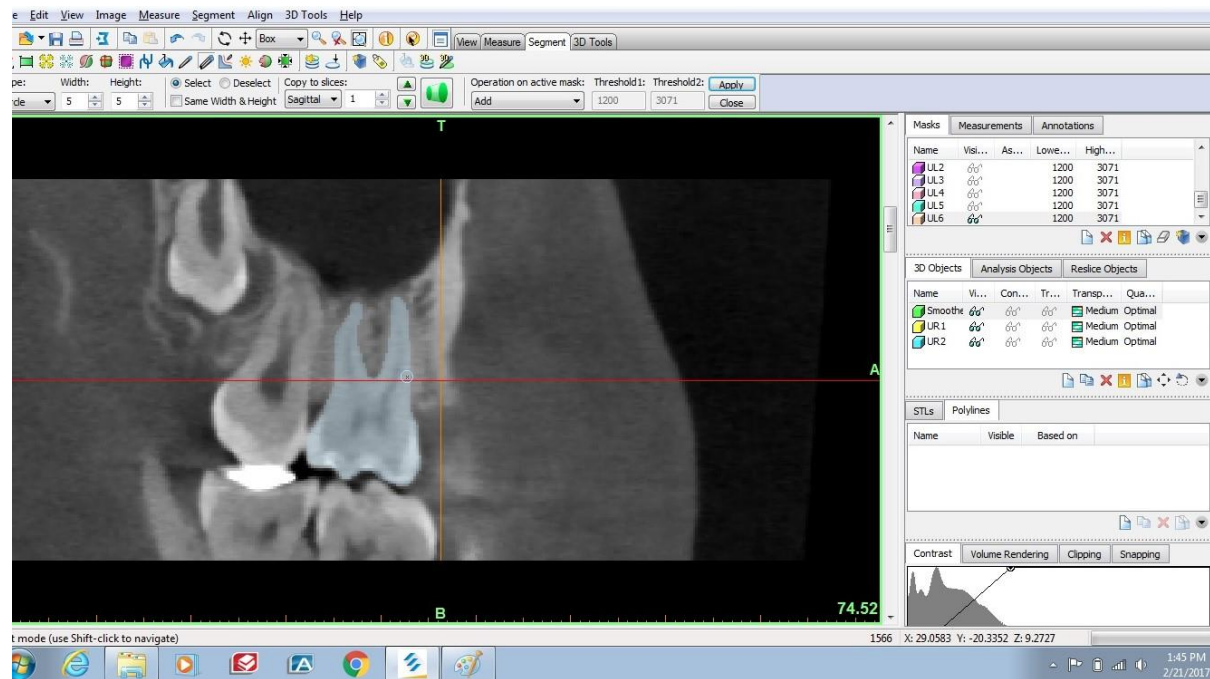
CBCT sagittal slice of maxillary first molar highlighted for addition to mask
